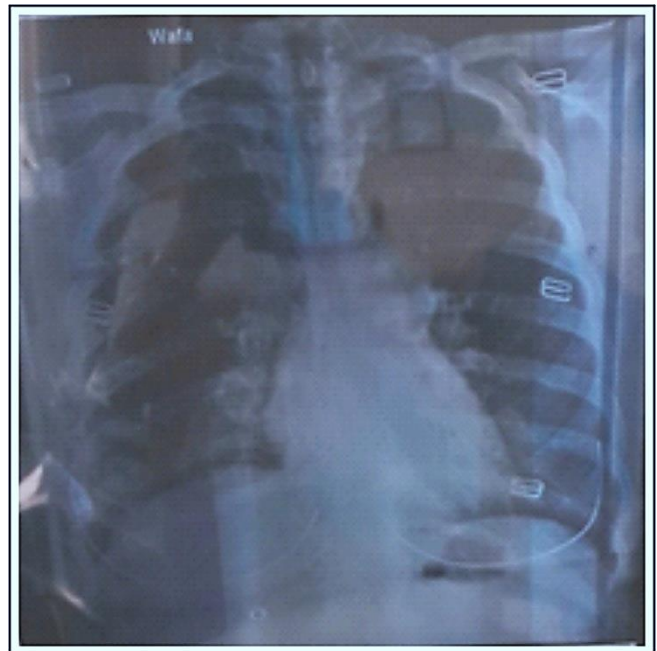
X-ray showing bilateral hilar lymphadenopathy in a patient with tattooing sarcoid.
